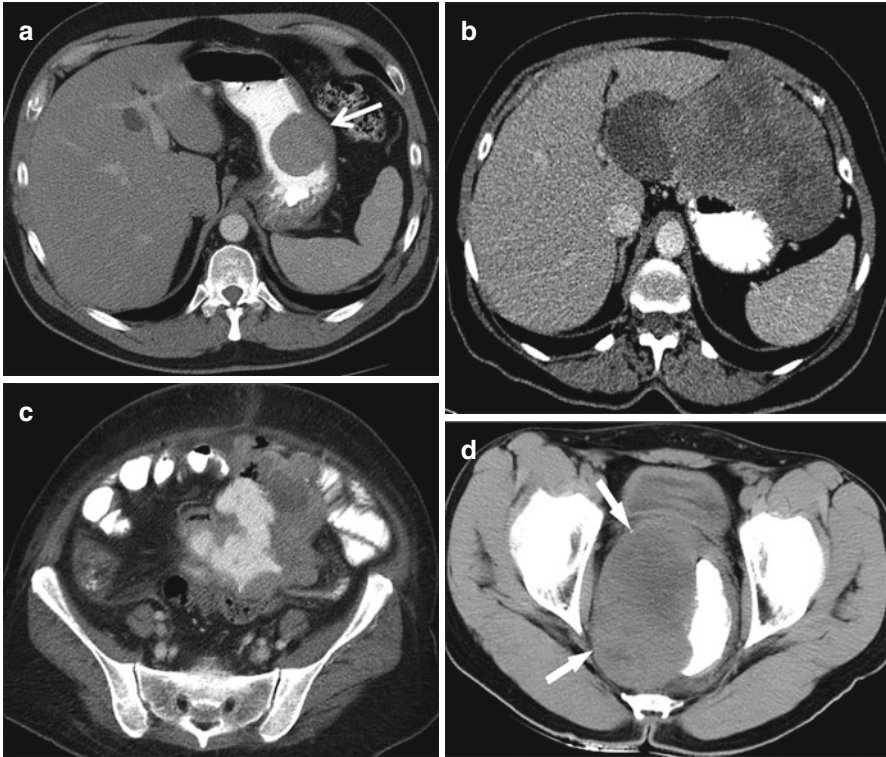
CT characteristics of GISTs. (a) Polypoid gastric GIST (*arrow*), (b) Exophytic gastric GIST (c) Exophytic small bowel GIST fistulizing to the bowel lumen note the contrast within the tumor cavity. (d) Rectal GIST (*arrow*).
